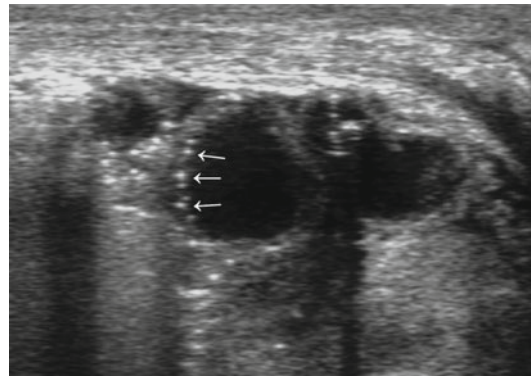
Ultrasound exam in newborn with NEC shows parietal pneumatosis in distended loops with small bubble of air in parietal loop seen as hyperechoic imaging along the wall (*white arrows*)
